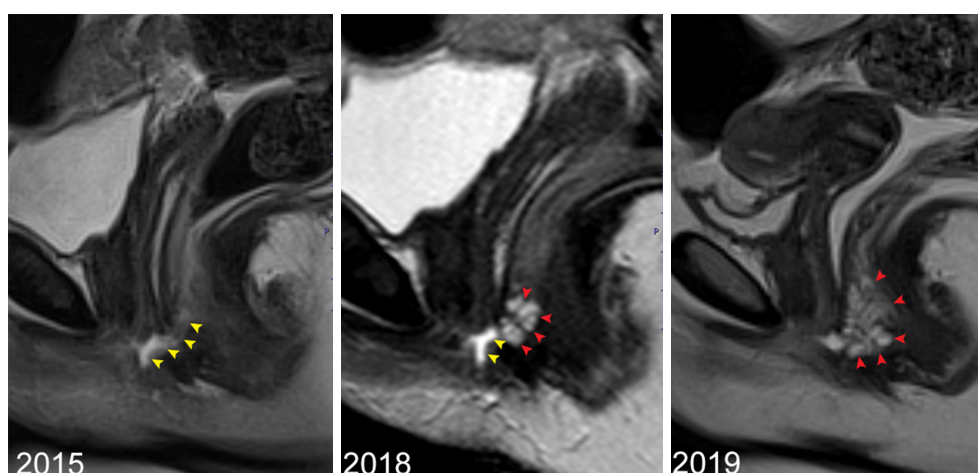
T2-weighted sagittal STIR MRI sequences in a male patient between 2015–2019. A micro-lobulated contour akin to ‘budding’ (red arrows) has developed over time from the fistula tract (yellow arrows). Clinical diagnosis of FMA was made in 2019. FMA, fistula mucinous adenocarcinoma; MRI, magnetic resonance imaging; STIR, short tau inversion recovery.
